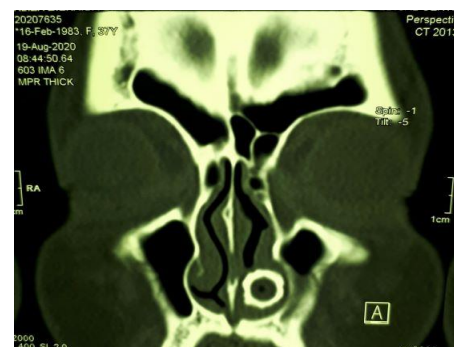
CT scan which showed left intranasal mass with calcification.
